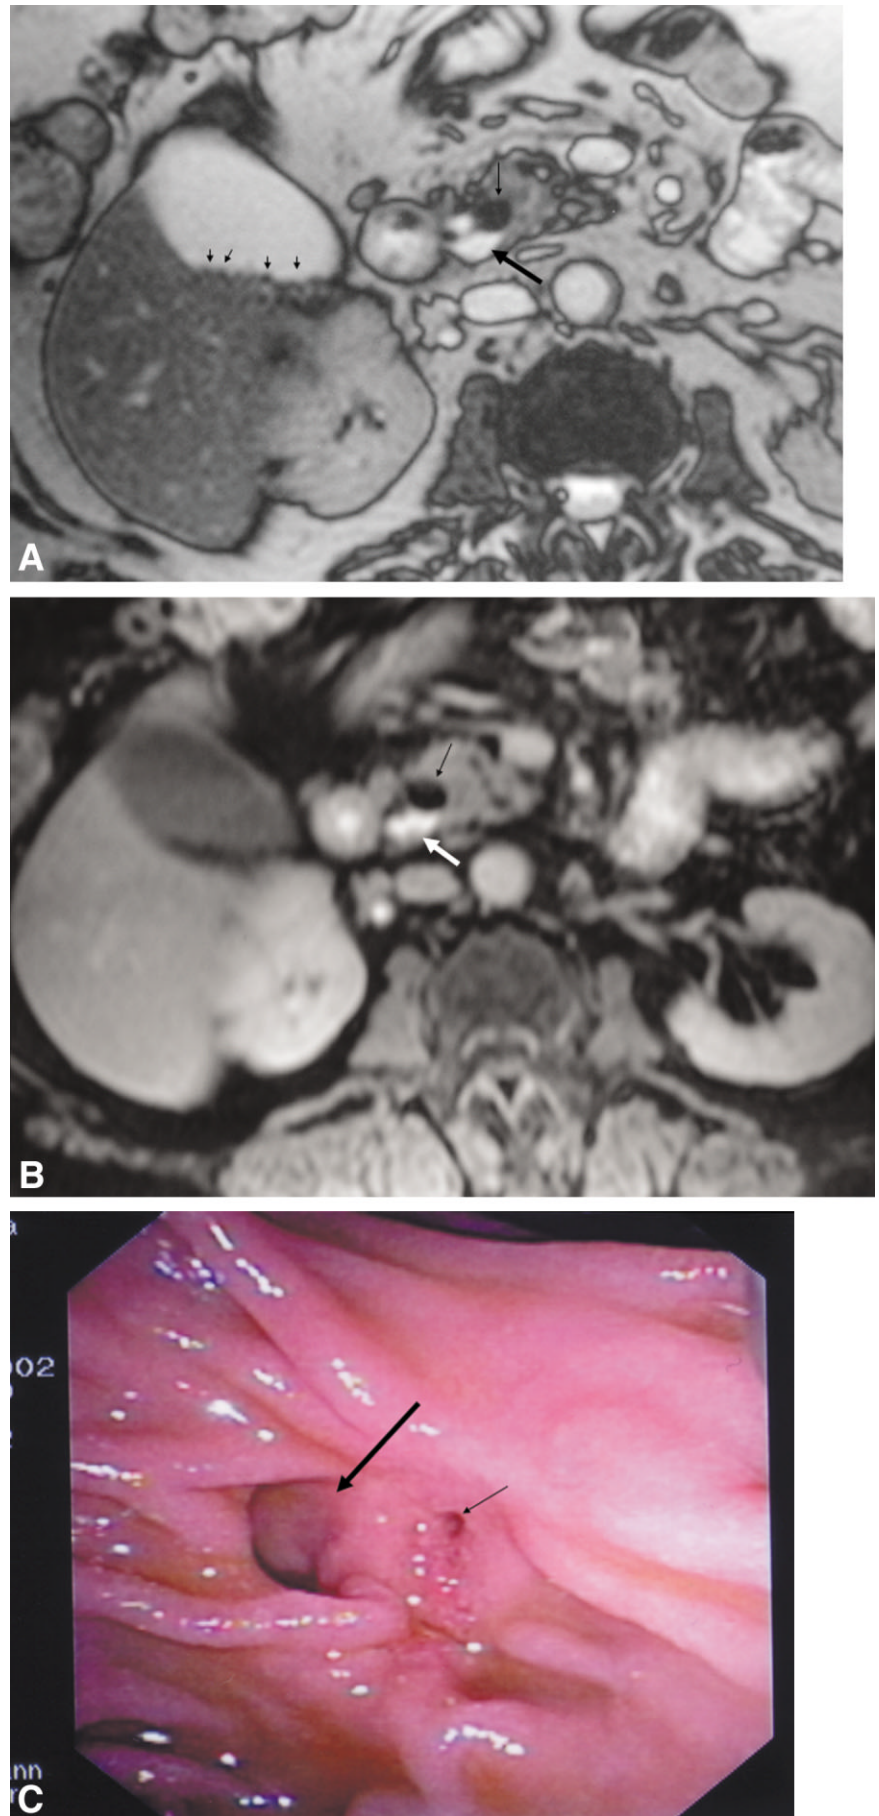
Small juxtapapillary diverticulum in a 67-year-old patient with multiple gallstones. T2-weighted True FISP image in the axial plane (TR = 3.6 msec, TE = 1.8 msec, FA = 70°) (a) reveals hyperintense fluid (long arrow) and a signal void air level (short arrow) within the diverticulum. Multiple small gallstones are observed in the gallbladder (small arrows). T1-weighted post-contrast fat suppressed spoiled gradient-echo image (TR = 165 msec, TE = 2.3 msec, FA = 70°) (b) in the axial plane reveals hyperintense fluid due to the oral contrast (white arrow), with a signal void air level above (black arrow). The corresponding endoscopic image during ERCP (c) demonstrates the diverticulum (long arrow) and its relationship to the papilla (short arrow).
